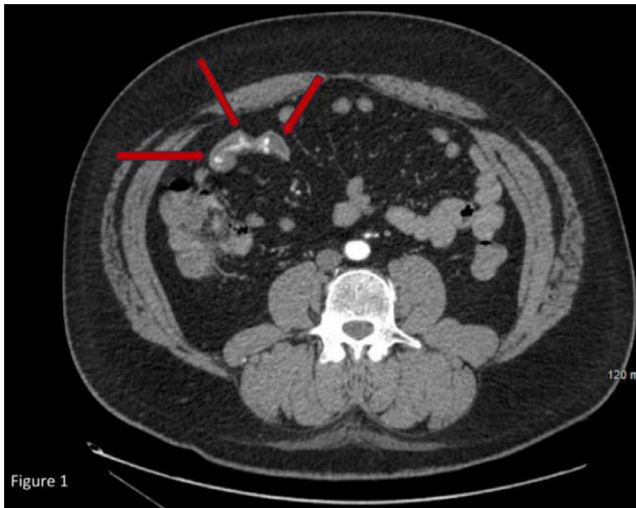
Representative axial CT scan slice of the abdomen in the arterial phase of a patient presenting with lower gastrointestinal bleeding, presyncope, and a drop in hemoglobin, demonstrating an area of active contrast extravasation from a blind-ending structure communicating with the terminal ileum, consistent with a bleeding MD.
